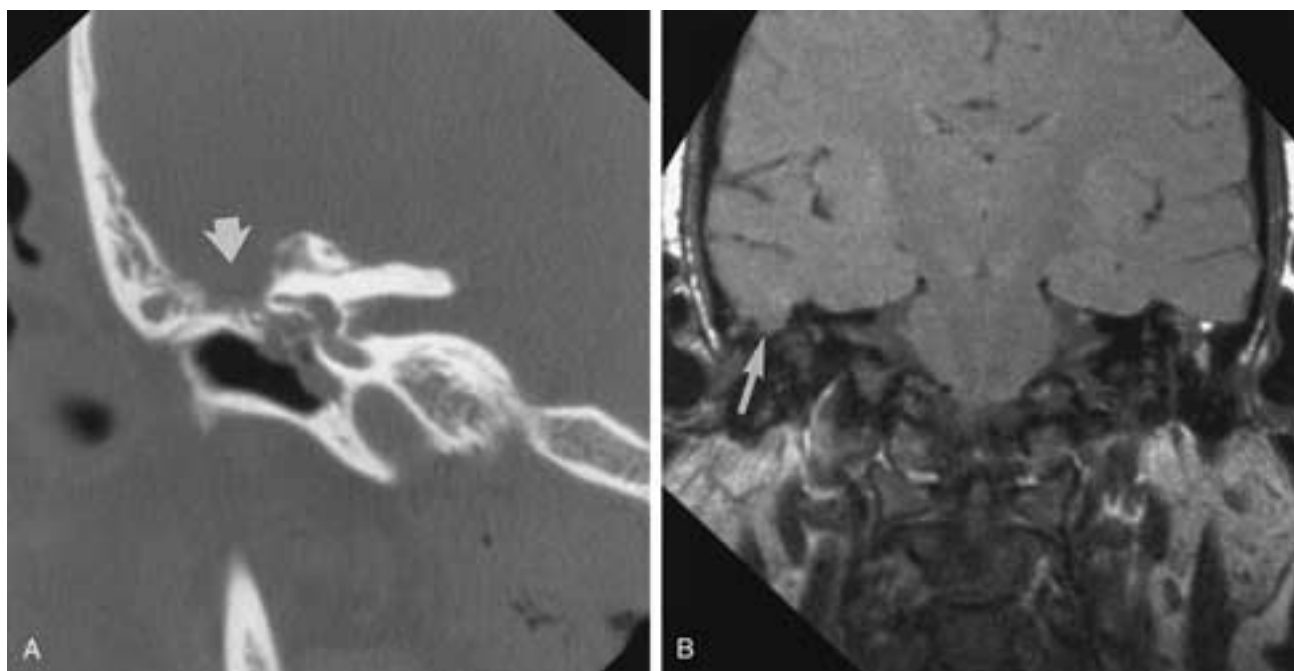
Erosive cholesteatoma with encephalocele. A, Coronal CT shows a mass in the middle ear with erosion of the tegmen (*arrow*). B, MR demonstrates herniation of brain through a defect in the tegmen (*arrow*).
